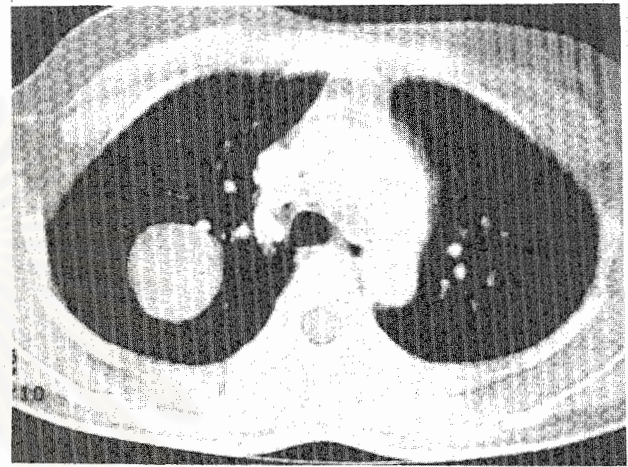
HRCT of the chest confirms a well-circumscribed, round mass in the right upper lobe. The lung parenchyma appears normal.
